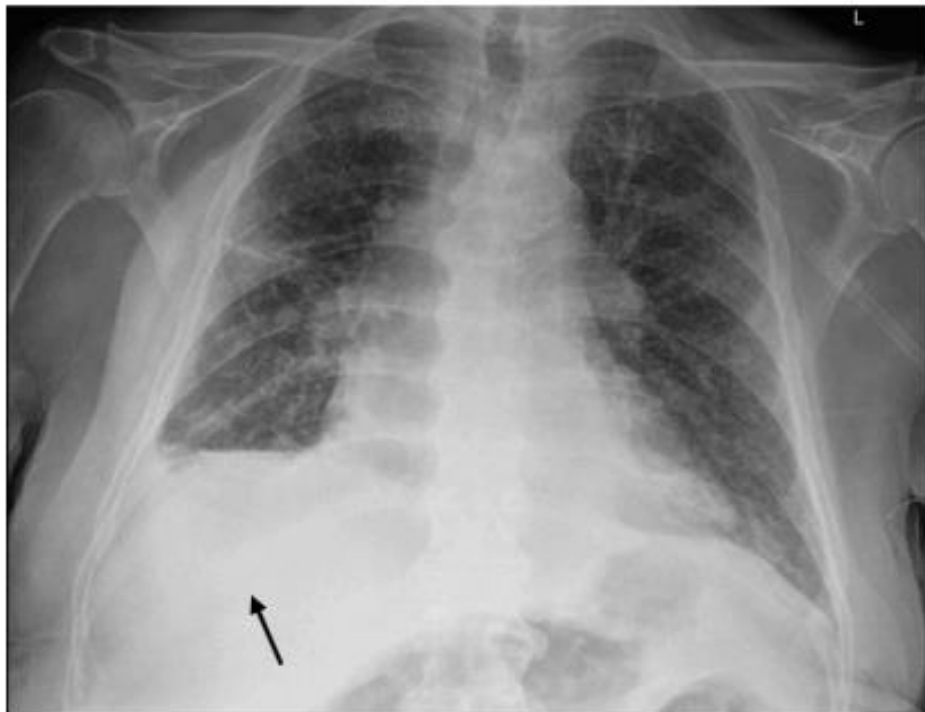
depicts the patient's chest x-ray, which revealed mild cardiomegaly, interstitial edema, pleural thickening, and a right sided infiltrate.
